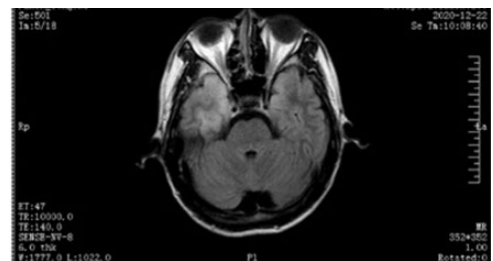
Cranial magnetic resonance imaging (MRI) showed abnormal signals in the bilateral temporal lobe, the hippocampus, and the bilateral external capsule.
